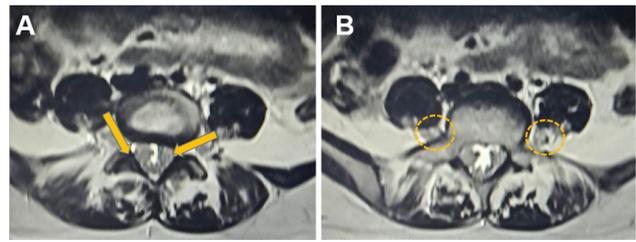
Axial T2-weighted images at L4–5 (A). Diffuse intradural thickening of the nerve roots causes marked circumferential narrowing of the dural sac, extending to the extramedullary component that expands the exit nerve roots. These combined features lead to spinal canal compression, as shown in (A), marked with yellow arrows. (B) Axial T2-weighted images at L5–S1. The canal is almost completely filled with hypertrophic nerve roots, with enlargement of the bilateral exit nerve roots (yellow circles). These findings highlight nerve-root hypertrophy, favouring CIDP over hereditary or neoplastic mimics. Axial images were included because they show segmental details of involvement and highlight the degree of canal compromise and nerve-root enlargement.
